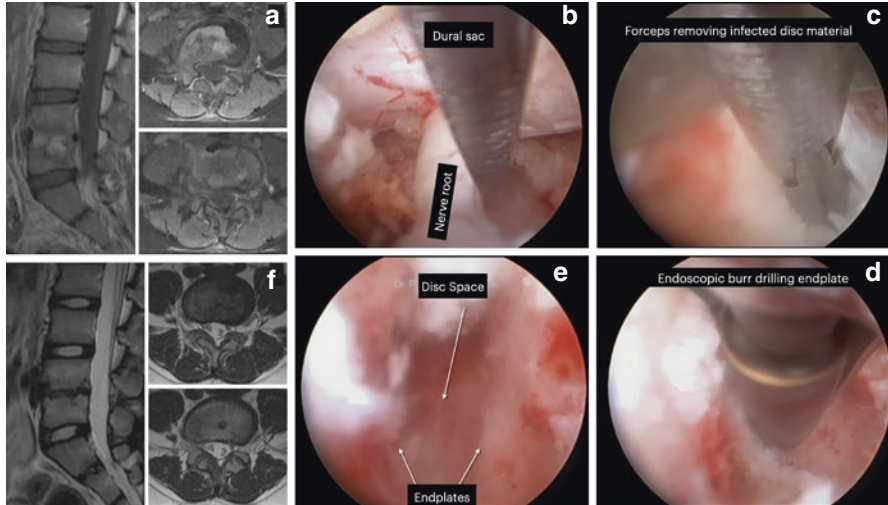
(a) Preoperative MRI pictures showing L4/5 disc space infection reaching up to anterior part of the disc space with moderate destruction of endplate. (b) Endoscopic picture showing nerve root being retracted by the dura dissector. (c) Endoscopic picture showing forceps removing infected tissue and disc material. (d) Endoscopic picture showing endoscopic burr removing some part of endplates to expose the abscess cavities hidden in the middle of disc space. (e) Endoscopic picture showing completely removed abscess cavity and well debrided disc space. (f) Postoperative MRI picture after 8 months showing complete resolution of infection without any instability
